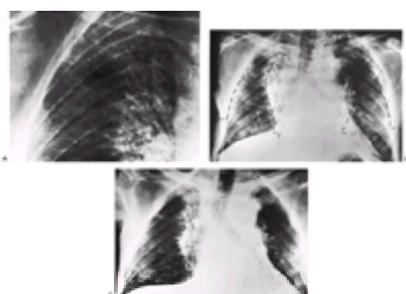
Roentgenograms of a 64-year-old man with stage IIA Hodgkin's disease. (A) 5-15-72. Detail of right apex showing early appearance of radiation pneumonitis 5 weeks after completion of mantle irradiation. (B) 5-28-71. The outline of the lung shields from a treatment film (taken supine) has been traced onto a diagnostic roentgenogram (taken erect) to show the close topographic correspondence between roentgenographic changes and the field of irradiation around the lung shields. The patient had dyspnea, cough, and pyrexia at this stage. (C) 1-18-73. Roentgenographic changes of radiation fibrosis in the paramediastinal, apical, peripheral, and left basal regions, again corresponding to the irradiated regions of the lung. (Reproduced from NJ Gross. *Ann Intern Med* 1977;86:81.)
